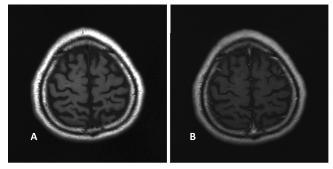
Axial T_1 -weighted magnetic resonance images at 26 months after onset without (A) and with (B) gadolinium injection demonstrating disappearance of the enhancing tumor.
